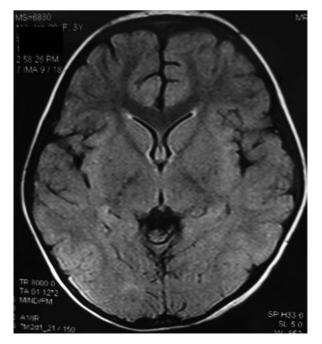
MRI brain T2 FLAIR sequence showing no obvious abnormality.
